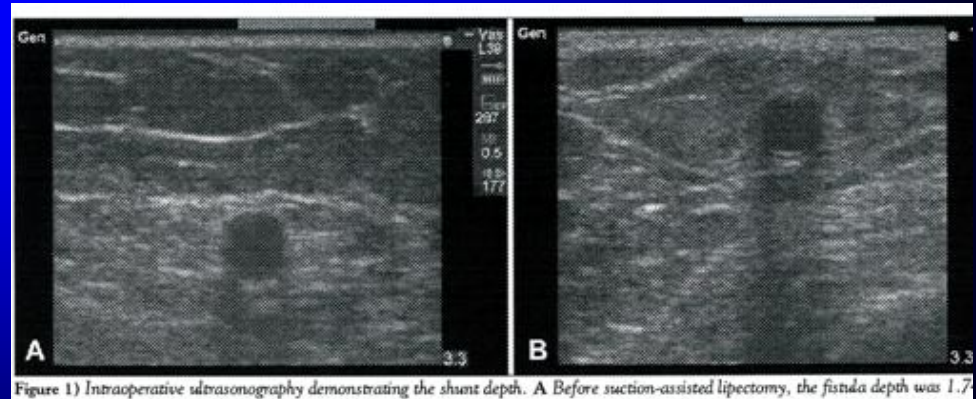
Intraoperative ultrasonography demonstrating the shunt depth. A Before suction-assisted lipectomy, the fistula depth was 1.7
